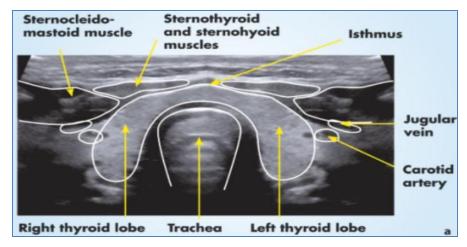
Normal thyroid ultrasound in transverse view (*Hofer*, 2013).
